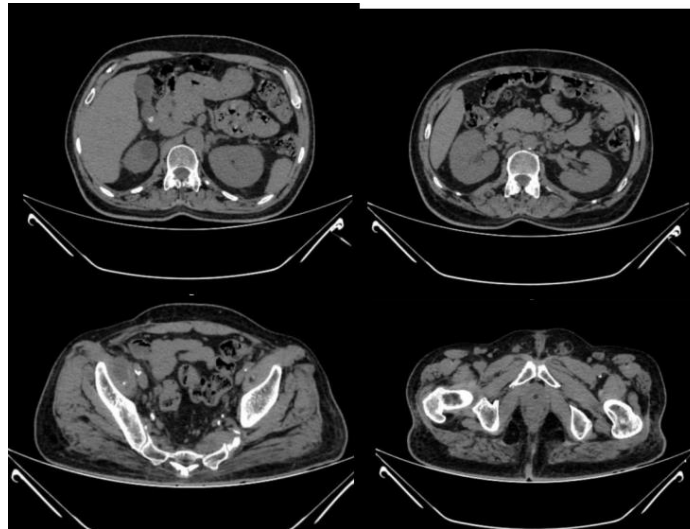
CT Abdomen findings
